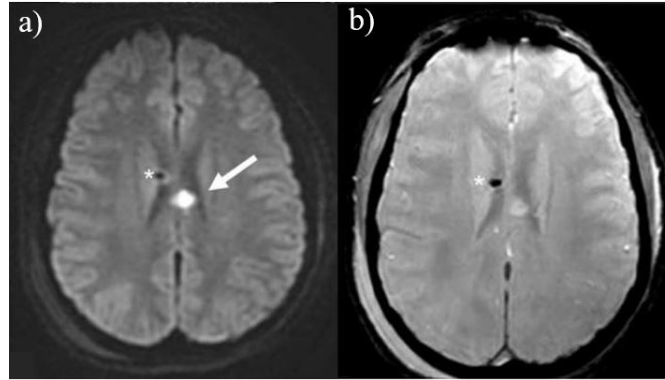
DWI (a) clearly demonstrates axonal injury in the left body of the corpus callosum while SWI (b) shows it much more subtly. A ventricular catheterization (asterisk) was performed during examinations. Source: Kazam et al. [33]*
